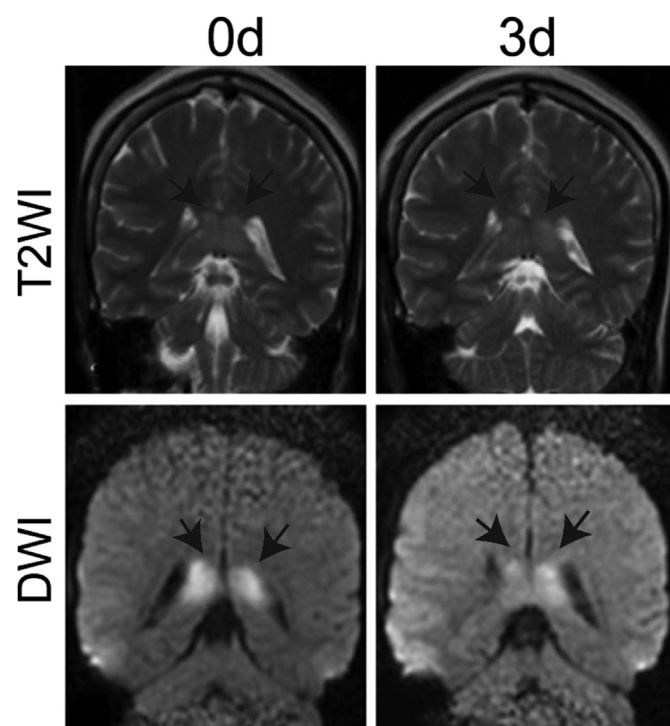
MR imaging of patient 1. On admission, T2-weighted image revealed lesions in the splenium of the corpus callosum, lesion was high signal on DWI.
